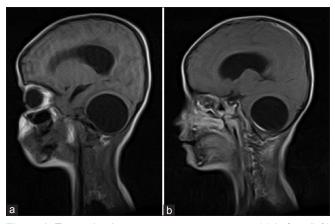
T1-weighted magnetic resonance imaging (a) before (left) and (b) after (right) contrast administration
